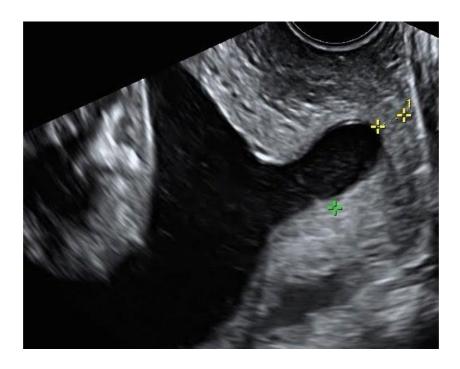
6 - TRANSVAGINAL ULTRASOUND SHOWING SHORT
